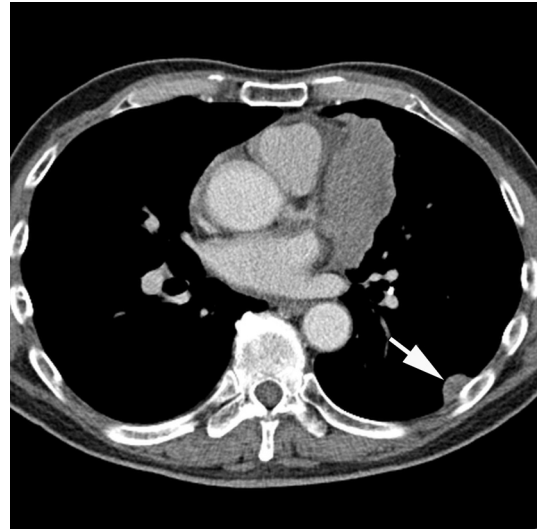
Invasive thymoma. Contrast-enhanced axial CT shows a heterogeneously enhancing left prevascular mediastinal mass with pericardial invasion and a left pleural metastasis (*arrow*).
